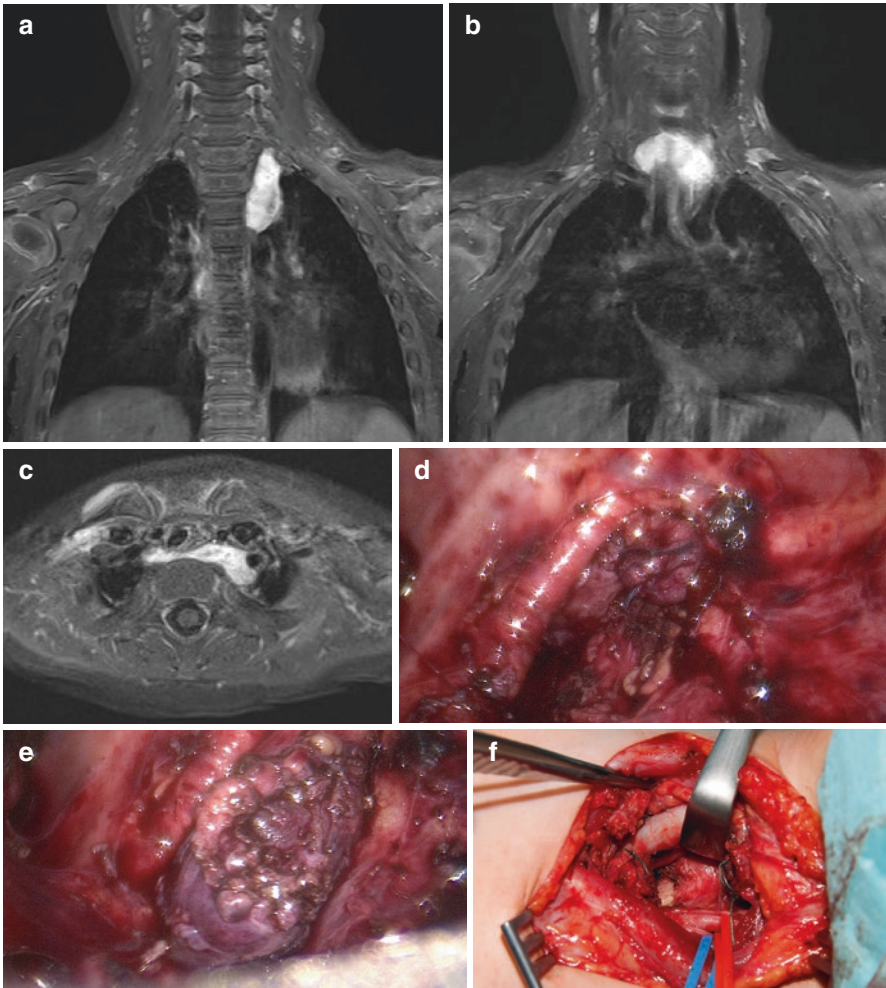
Cervico-thoracic left-sided neuroblastoma in a child with Opsomyoclonus Syndrome. (a-c) Preoperative MRI Scan showing thoracic and cervical tumor compounds. (d) View during thoracoscopic tumor dissection;
